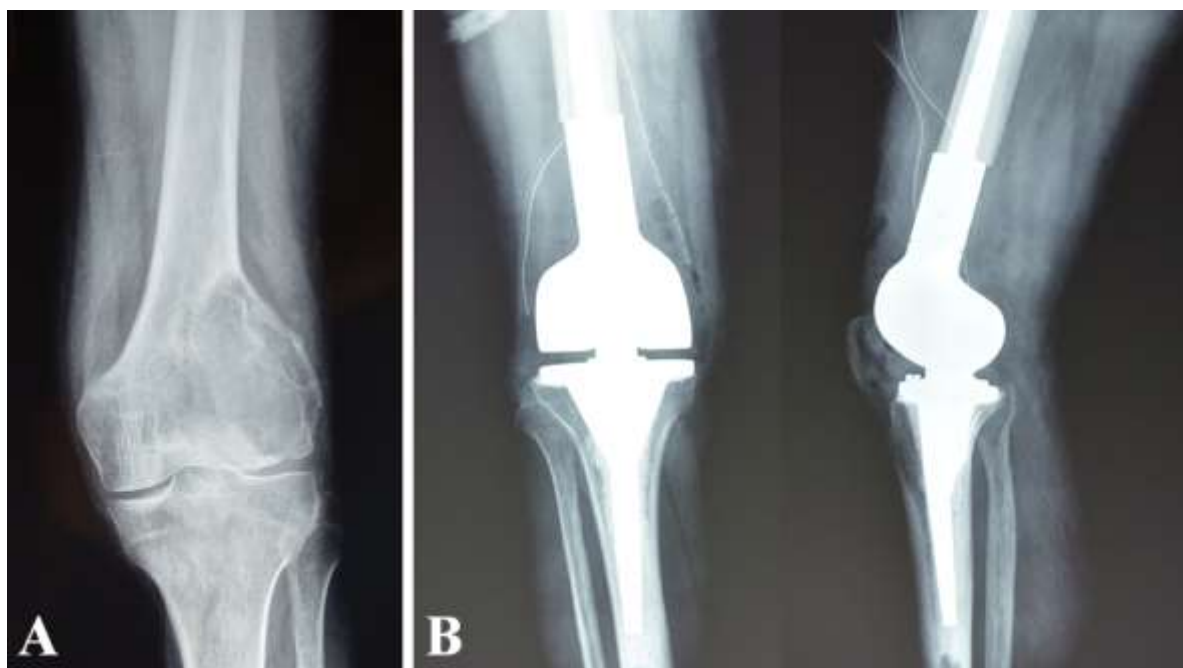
(A) Preoperative AP view X-ray of a giant-cell tumor of the right knee; (B) Postoperative AP and LL view X-rays: arthroplasty with modular tumoral prosthesis.
